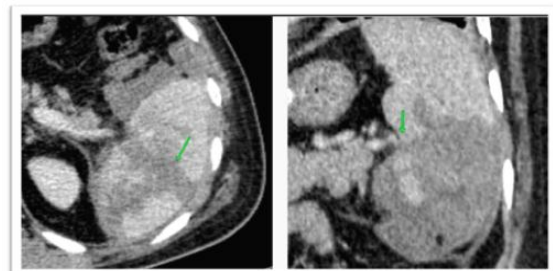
Contrast-enhanced CT of the abdomen showing an AAST Grade V (shattered) spleen with non-enhancing lacerations involving 50–60% of the parenchyma, segmental vessel involvement, and hemoperitoneum.
